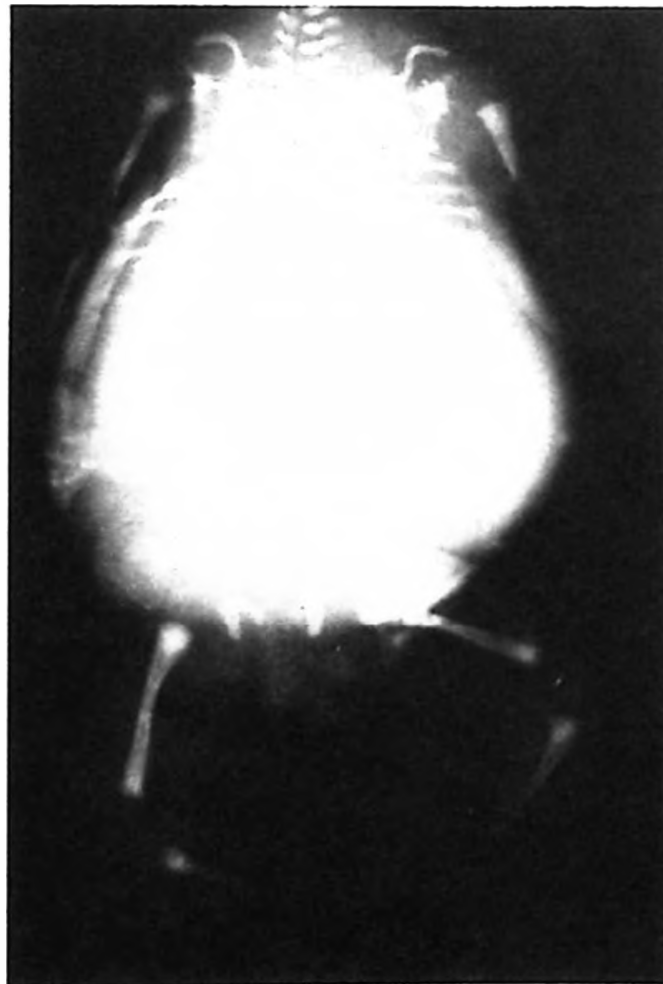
Postmortem X-ray demonstrates deformed, short ribs on the right side of the fetus.
